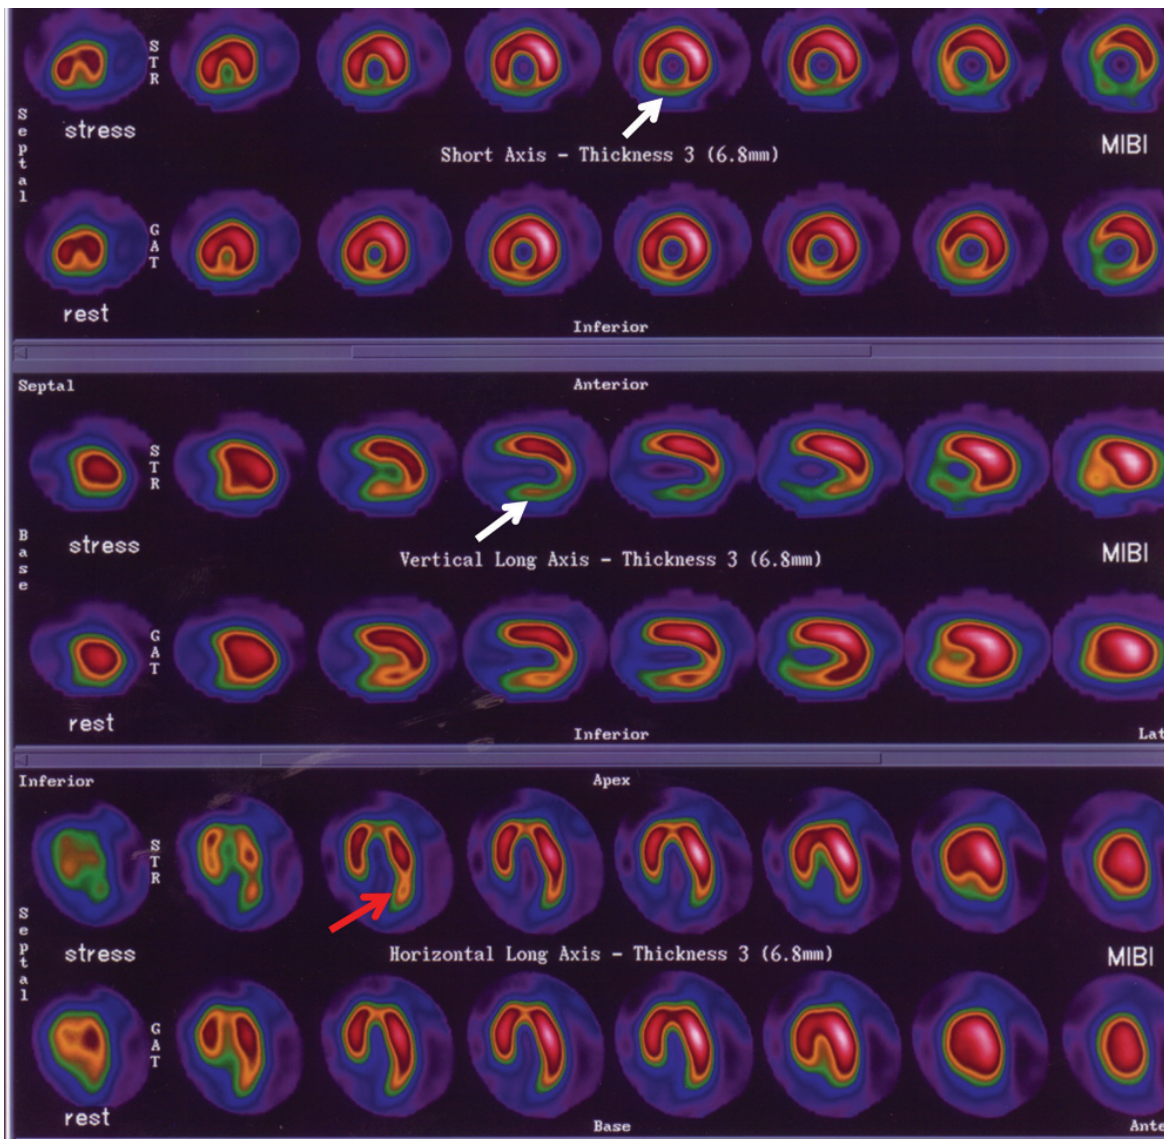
MIBI SPECT of a patient after MCT. An inferior reversible defect (white arrows) and a lateral reversible defect (red arrow) are shown. A coronary angiogram revealed an absence of coronary obstructions.
